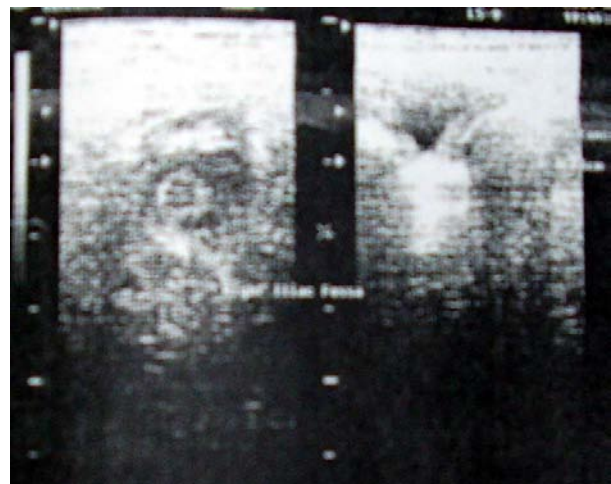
Transverse sonogram of acute appendicitis shows target sign and periappendiceal collection.
